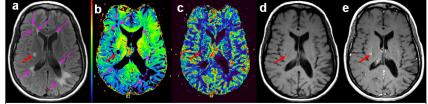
MS lesions for subject 1. a)FLAIR; b) TSM-nulling lesion; c) rCBV; d) pre-contrast T1 weighted Imaging; e) post-contrast T1 weighted imaging. The pink arrows point the chronic lesions in FLAIR (a) and TSM (b). The lesion pointed by red arrow is acute as seen enhanced in post-contrast T1 (e).
